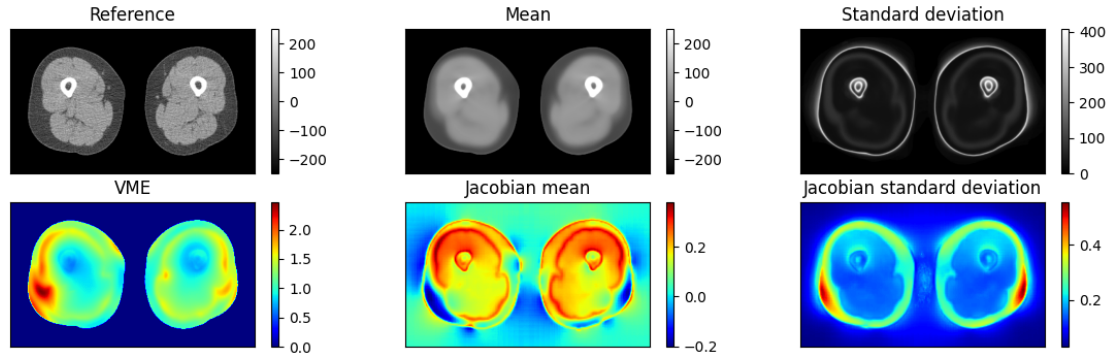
Resulting collage for the thigh registration of 4603 CT scans. (Reference) shows the preprocessed reference image. (Mean) shows the mean intensity of all registered images. (Standard deviation) shows the intensity standard deviation of all registered images. (VME) visualise the mean VME for all registrations. (Jacobian mean) visualise the mean of the logarithm of the Jacobian in every point. (Jacobian standard deviation) show the standard deviation of the logarithm of the Jacobian in every point. For visibility purposes the intensity scale of the reference and mean images have been changed from -1024 HU to 1024 HU to -250 HU to 250 HU. VME = Vector magnitude error.
